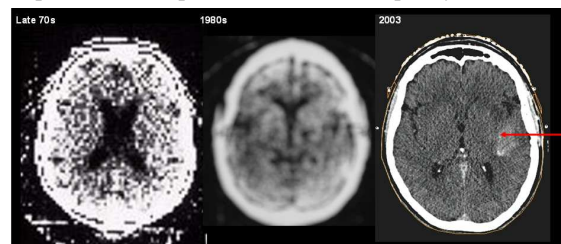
Advances in brain imaging mean that small tumours can now be identified. The arrow is pointing to a glioblastoma which is now clearly visible on the most modern CT brain scan.
